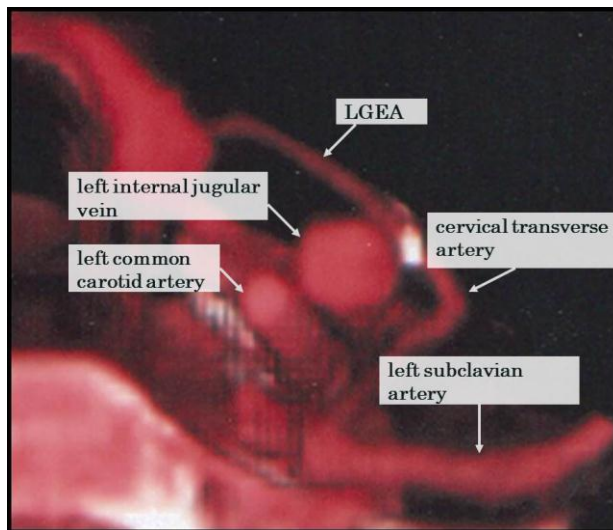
Three-dimensional computed tomography.
